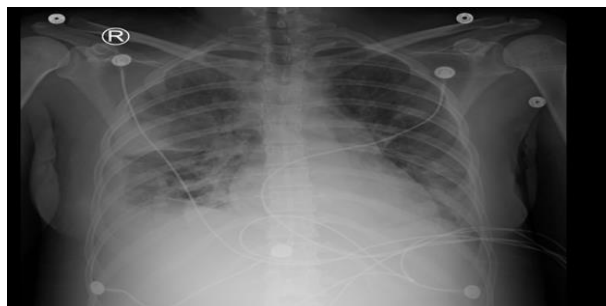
Followup chest X-ray showing progressive worsening with bilateral hazy and consolidative patchy opacities, right greater than left, with moderate right and trace to small left-sided pleural effusions, noted.
